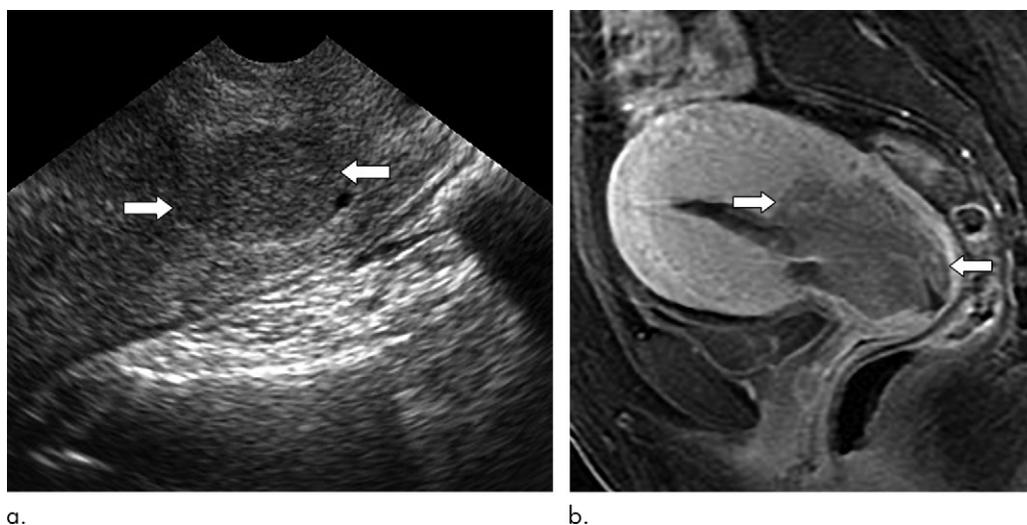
Images show uterine cervical cancer size at US versus MRI. (a) Sagittal endovaginal US image in a woman presenting with abnormal uterine bleeding shows 2.3-cm solid mass (arrows), pathologically diagnosed as invasive adenocarcinoma and initially staged as IB2. (b) Sagittal MRI after gadolinium-based contrast agent administration shows that tumor (arrows) extends into uterine corpus and measures 4.8 cm, corresponding to stage IB3.
